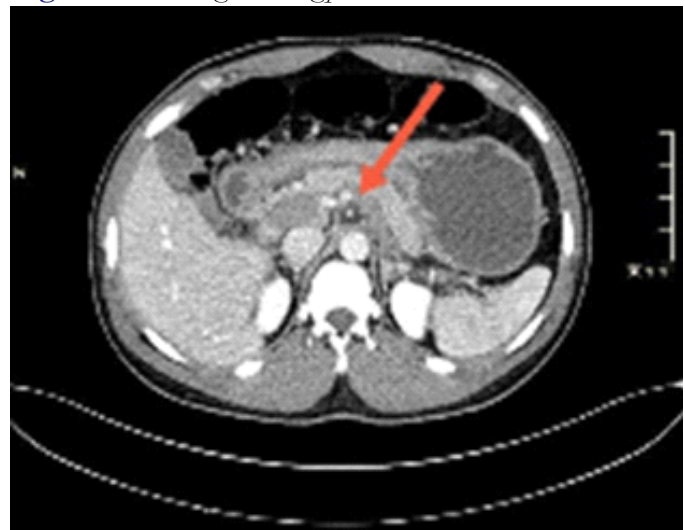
CT image showing splenic vein thrombosis
